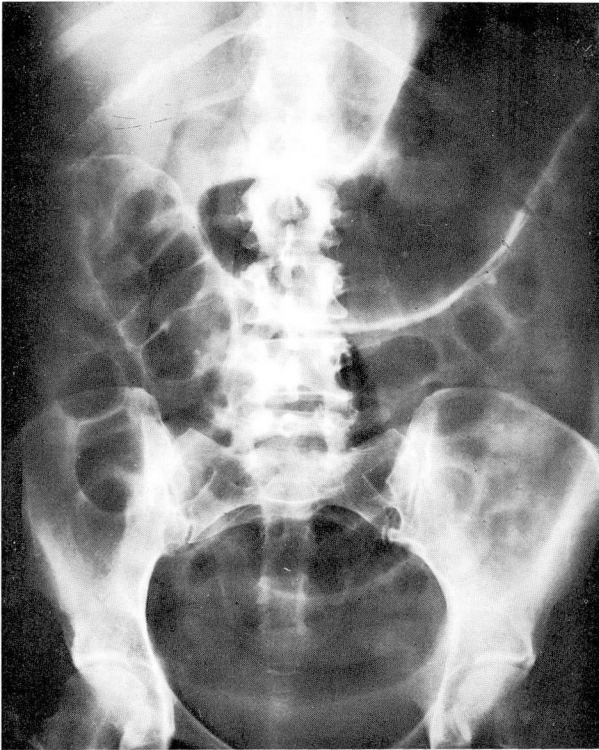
Roentgenogram of the abdomen on December 13, 1964, with the patient supine. A large distended stomach and minimal distention of the large and small bowel are evident. (Courtesy of Charles E. Staats, M.D., Charleston, West Virginia.)
